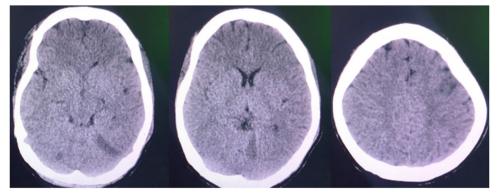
Computed tomography scan of the brain (Plain): Acute infarcts on left frontoparietal lobes and both cerebellar hemispheres
